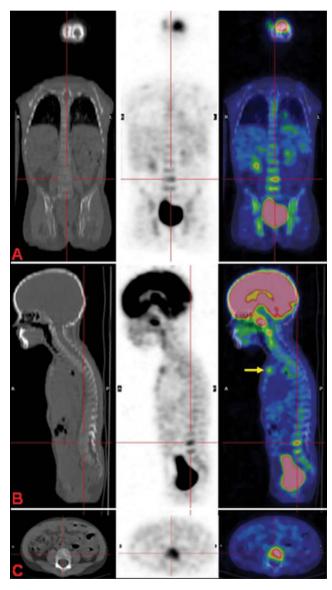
Coronal (A), axial (B) and sagittal (C) CT, ¹⁸F-FDG PET, PET/CT fusion images showing abnormal uptake in the soma of the 4th, 5th lumbar vertebrae and S1, and an additional site of disease not revealed by MRI in the sternum (yellow arrow in the sagittal PET/CT fused image)
